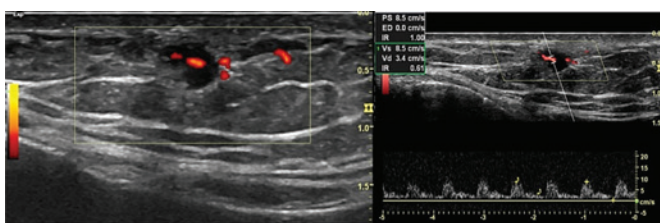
The nodule shows easy central flow uptake on the Power Doppler study (left), with a low resistance arterial flow pattern to the Spectral Doppler study (right).
